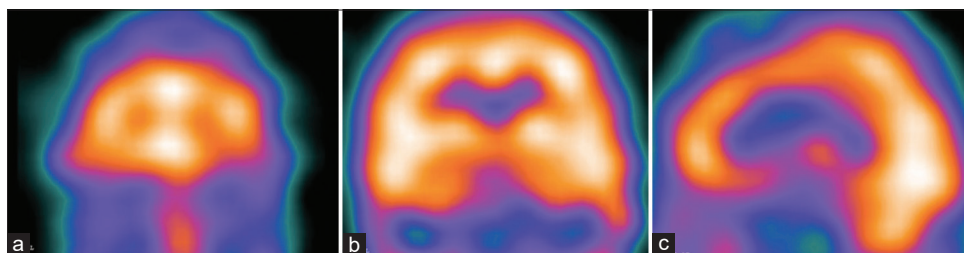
Preoperative single-photon emission computed tomography coronal (a and b) and left side sagittal (c) slices of patient 3 showing hyperperfusion of the anterior cingulate gyri, orbitofrontal cortices, dorsolateral prefrontal areas, temporal lobes, left basal ganglia, and left parietal lobe.
